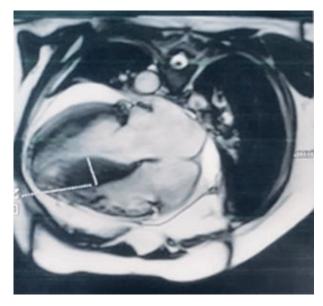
Cardiac MRI shows asymmetric septal hypertrophy
